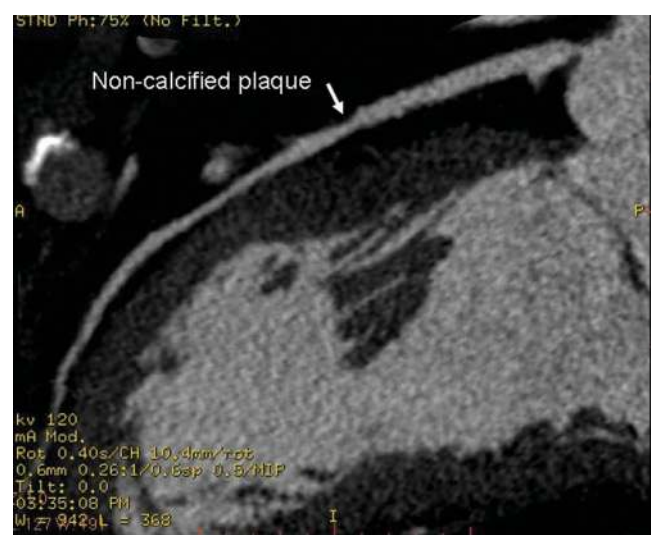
Coronary CT angiography of non-calcified plaque. A non-calcified plaque is found at the mid-segment of the left anterior descending artery on a curved planar reformatted image. (Reproduced from [127].)
